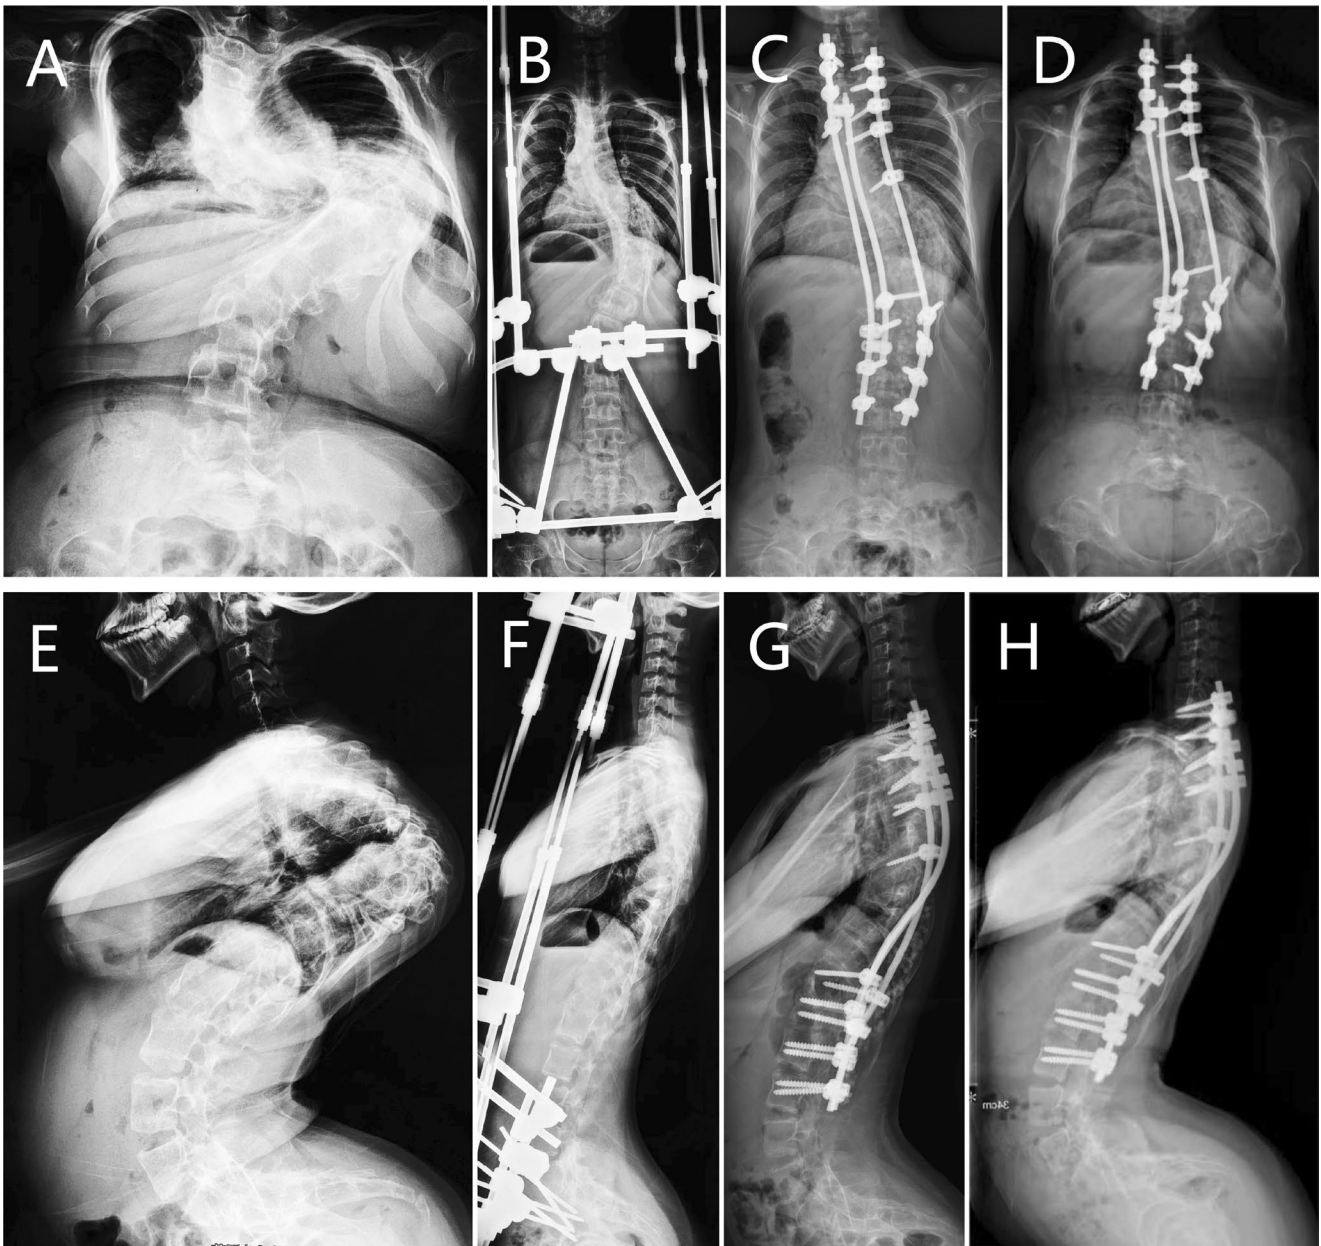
Whole spine x-rays of Patient 4. (A, E) X-rays at the initial visit showing a thoracic curve of 89°, a thoracolumbar curve of 95°, and a T5 to T12 thoracic curve of 101°. (B, F) X-rays after the halo-pelvic device was applied. (C, G) Immediate postoperative x-rays after the correction surgery, following a 3-month traction. (D, H) X-rays at the latest follow-up.
